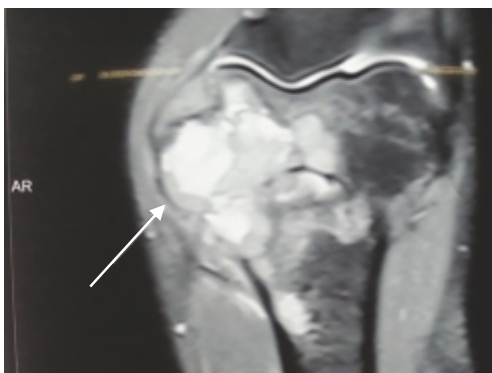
T2W MRI Image showing Lytic Foci at the Medial Epicondyle with Fluid Level within the Lesion
